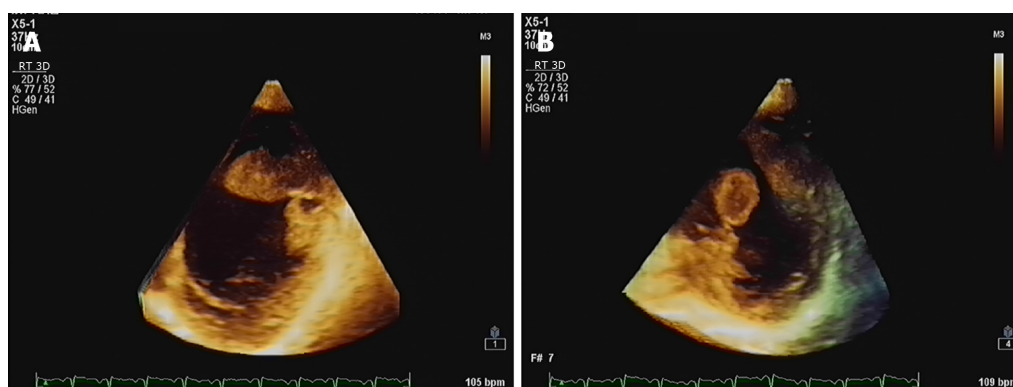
Still image derived from three-dimensional echocardiography. A: Thrombus protruded from the lateral wall of the left ventricle with a wide base; B: Thrombus with short and thin stem protruded from the left ventricular apex.
